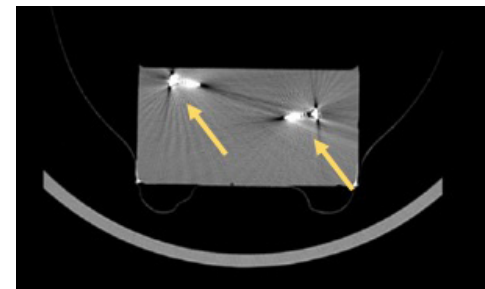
CT of the model. Metallic dental screws.
